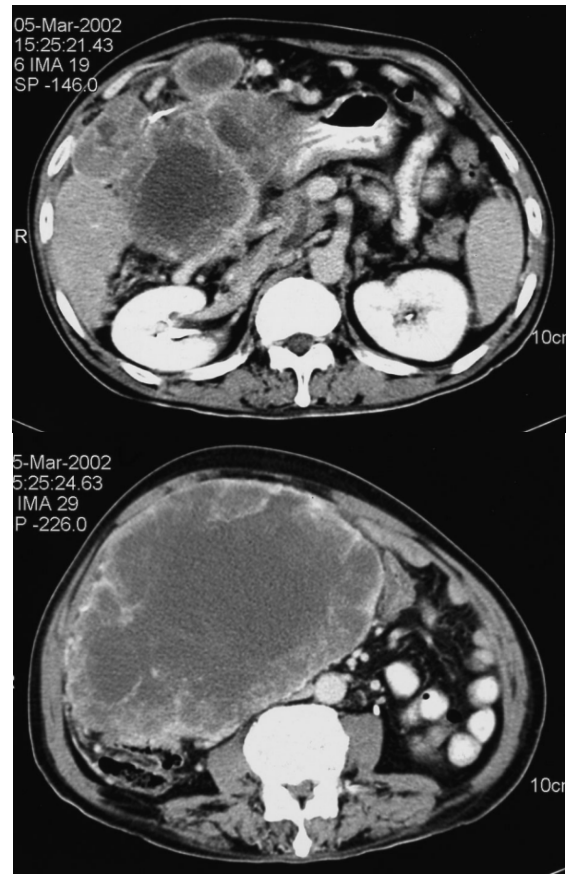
Abdominal CT scan(9 months later) shows enlargement of the metastatic nodules(Fig4-a). The largest one is up to 23 cm in diameter(Fig4-b).
